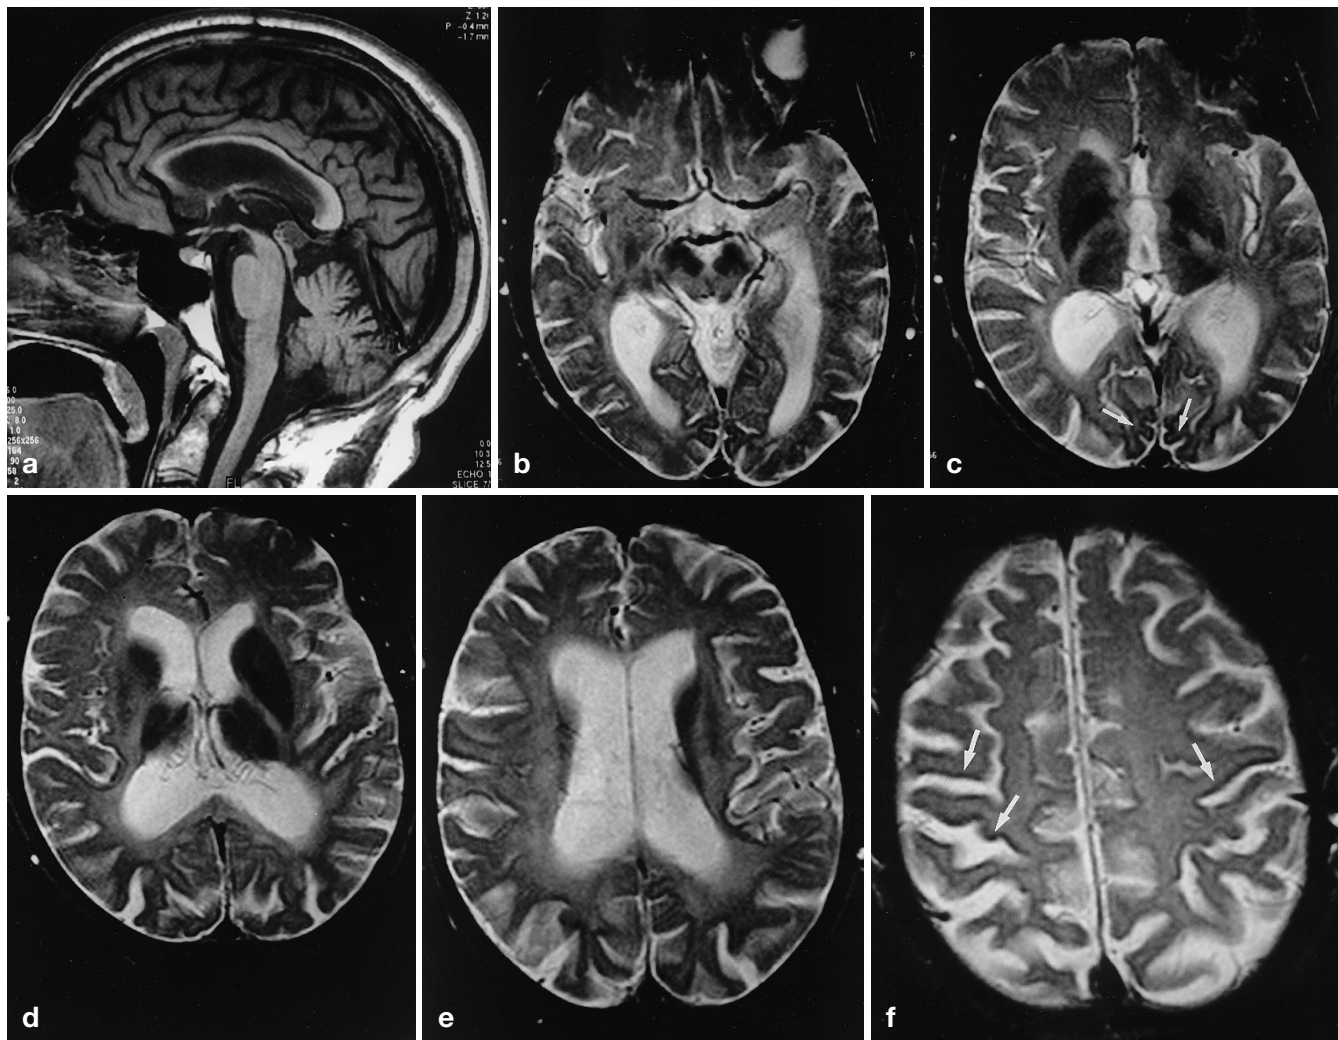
Conventional spin-echo images. a Sagittal noncontrast T1-weighted (500/16). Cerebral atrophy is seen, most prominent in the corpus callosum and cerebellar vermis. b–e Axial T2-weighted (2000/100). There is generalized atrophy (enlarged ventricles and sulci), loss of gray-white matter distinction, and diffuse paraventricular white matter high signal. Bilateral low signal foci are present in the caudate, putamen, globus pallidus, red nucleus, substantia nigra, and thalamus. In addition, low signal is seen in lobar gray matter, most prominently the medial occipital (*c*, arrows), posterior frontal (*f*, arrows) and peri-Rolandic parietal cortex. Mild low signal was also seen in the basis pontis bilaterally. There was not abnormal contrast enhancement
